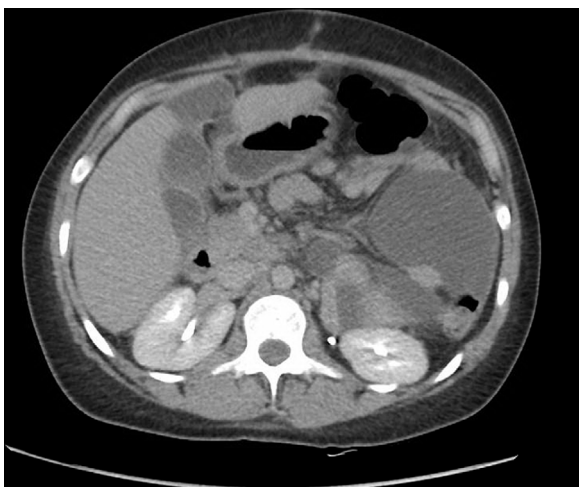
CT Abdomen showing biloma formation.
